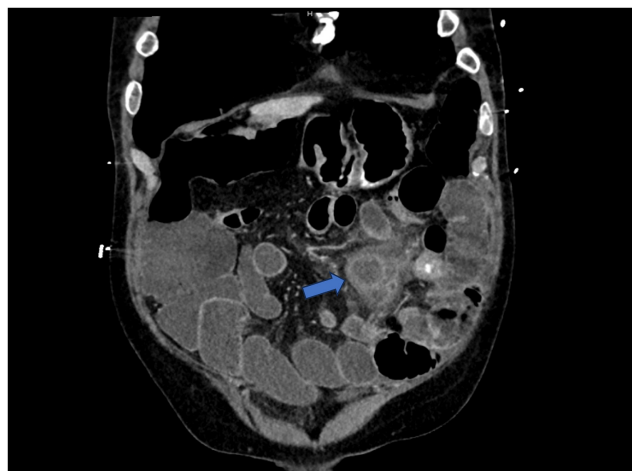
CT abdomen and pelvis with IV contrast, coronal view, showing contained perforation with inflammatory changes (blue arrow) located posteriorly and to the left of the decompressed loop of the small intestine in Figure 1.
